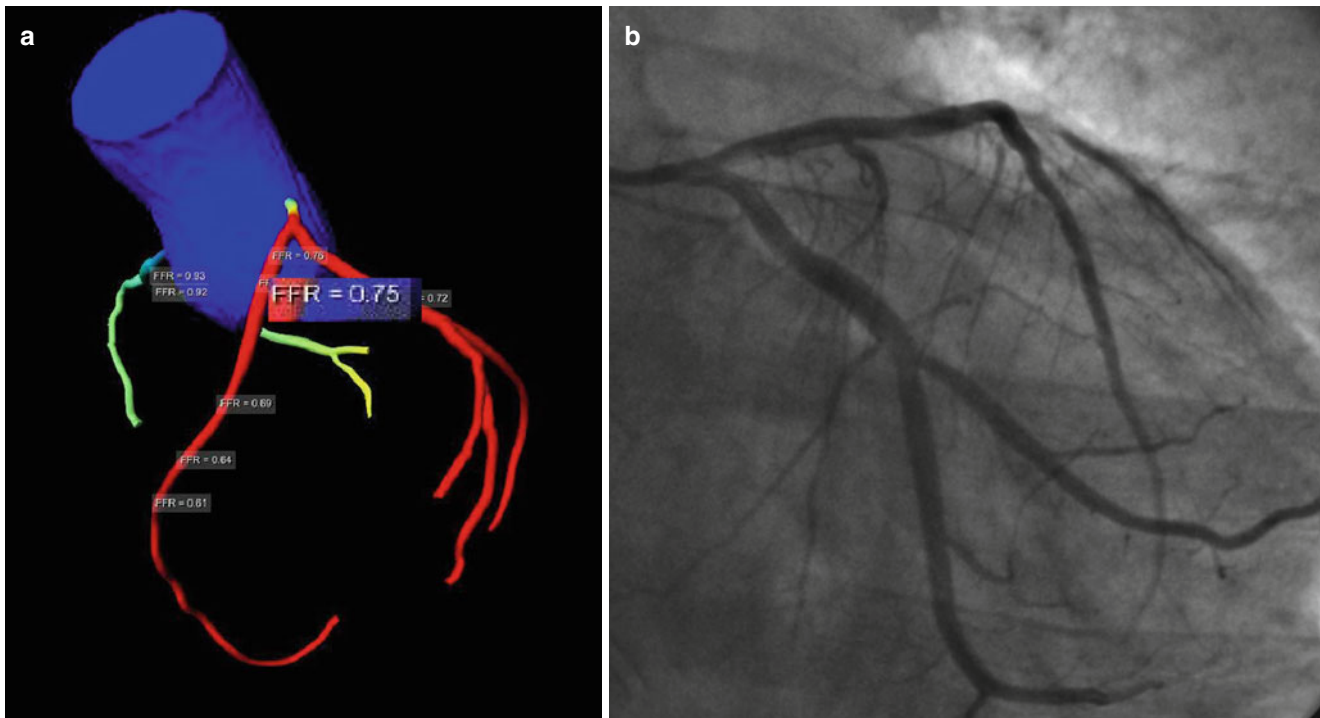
CT-fractional flow reserve. CT-FFR of the LAD was 0.75 at the proximal LAD (a), real FFR was 0.70 at the proximal LAD (b)
